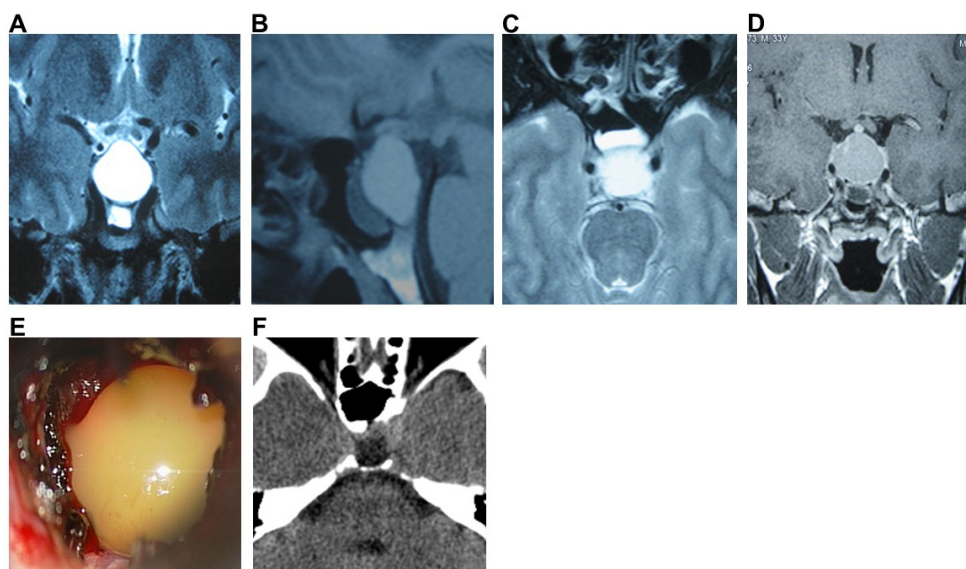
Preoperative pituitary MRI, intraoperative image and postoperative CT of Case 4. Preoperative coronal (A), sagittal (B), and axial (C) MRI plain scans showed cystic lesions in the sellar region, low signal on T1WI, high signal on T2WI. The mucosa of the sphenoid sinus at the sellar floor was significantly thickened. Submucosal effusion was observed. Preoperative coronal (D) enhanced MRI scan showed partial enhancement of the cyst wall. During operation (E), the pus was yellow and viscous. Postoperative head CT (F) showed no recurrence of the pituitary abscess.
